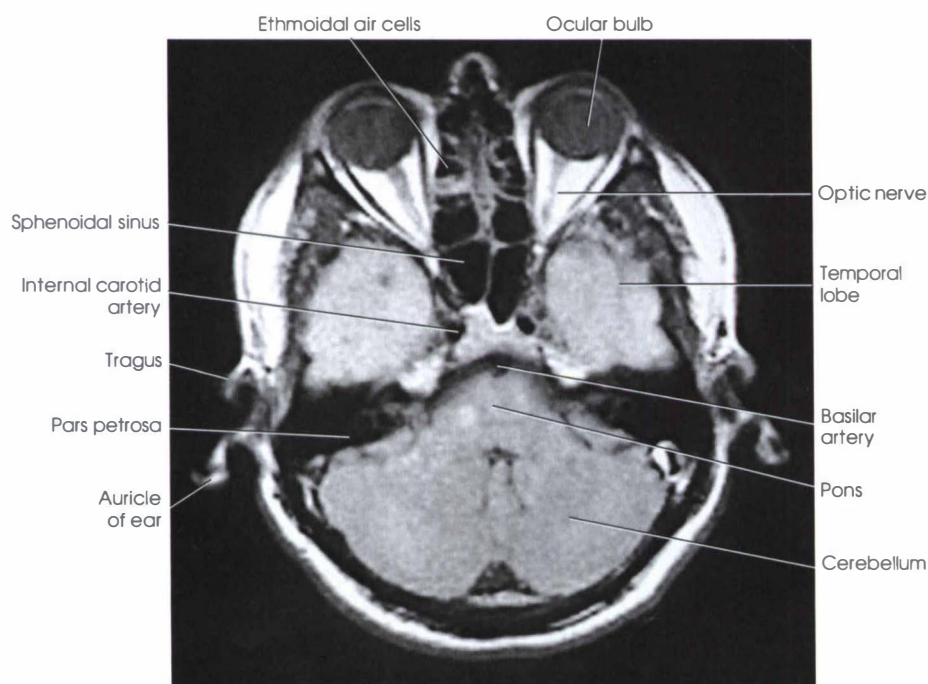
MRI representing the anatomic structures located at level C in Fig. 27-1.
